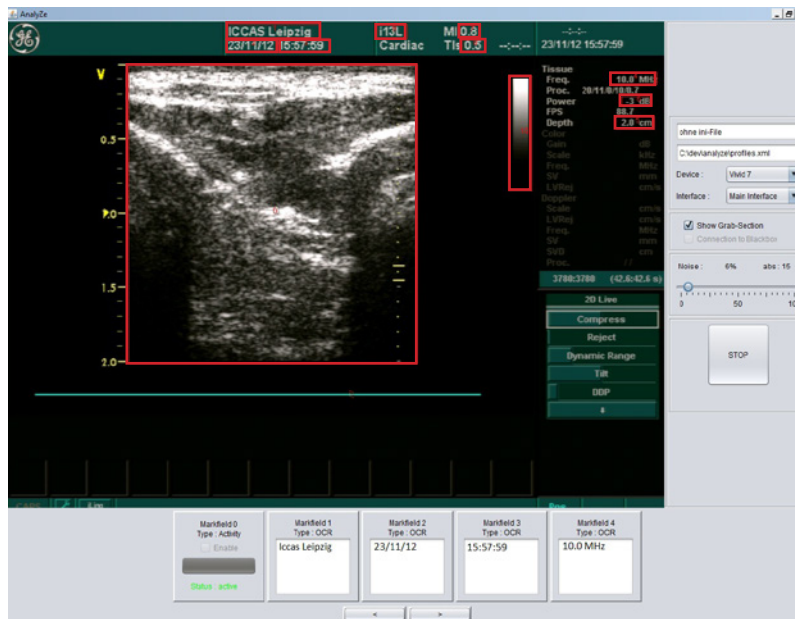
Graphical user interface of the analyzing software. The red areas indicate the analyzed fields. Depending on the type of the marks, different analysis algorithms are used. In this picture the ultrasound device is currently in use. The analyzing software monitors the relevant areas and stores the extracted information into the surgical recorder
